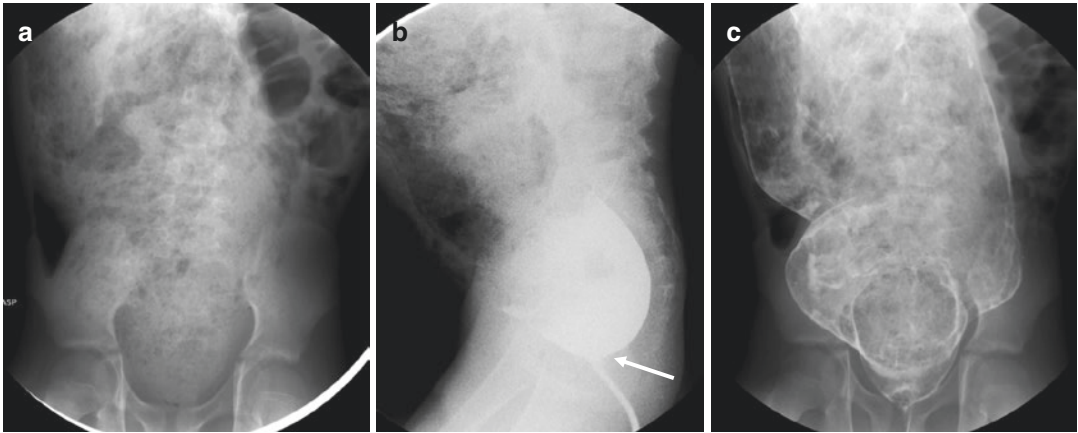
Hirschsprung disease in a 12-year-old boy with history of severe constipation. Chronic intestinal obstruction was suspected. The diagnosis of Hirschsprung disease was achieved based on water-soluble contrast enema. (a) Abdominal radiograph demonstrates fecal
